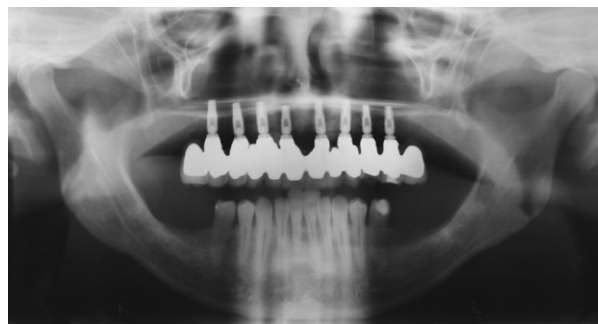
Panoramic radiograph showing implant-supported restorations.
